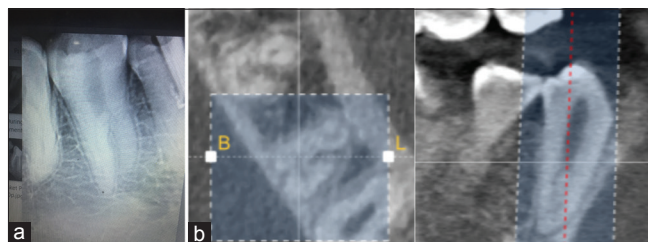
(a) Preoperative X-ray of lower right second premolar. (b) Cone-beam computed tomography of 45 confirmed three roots and three root canals
